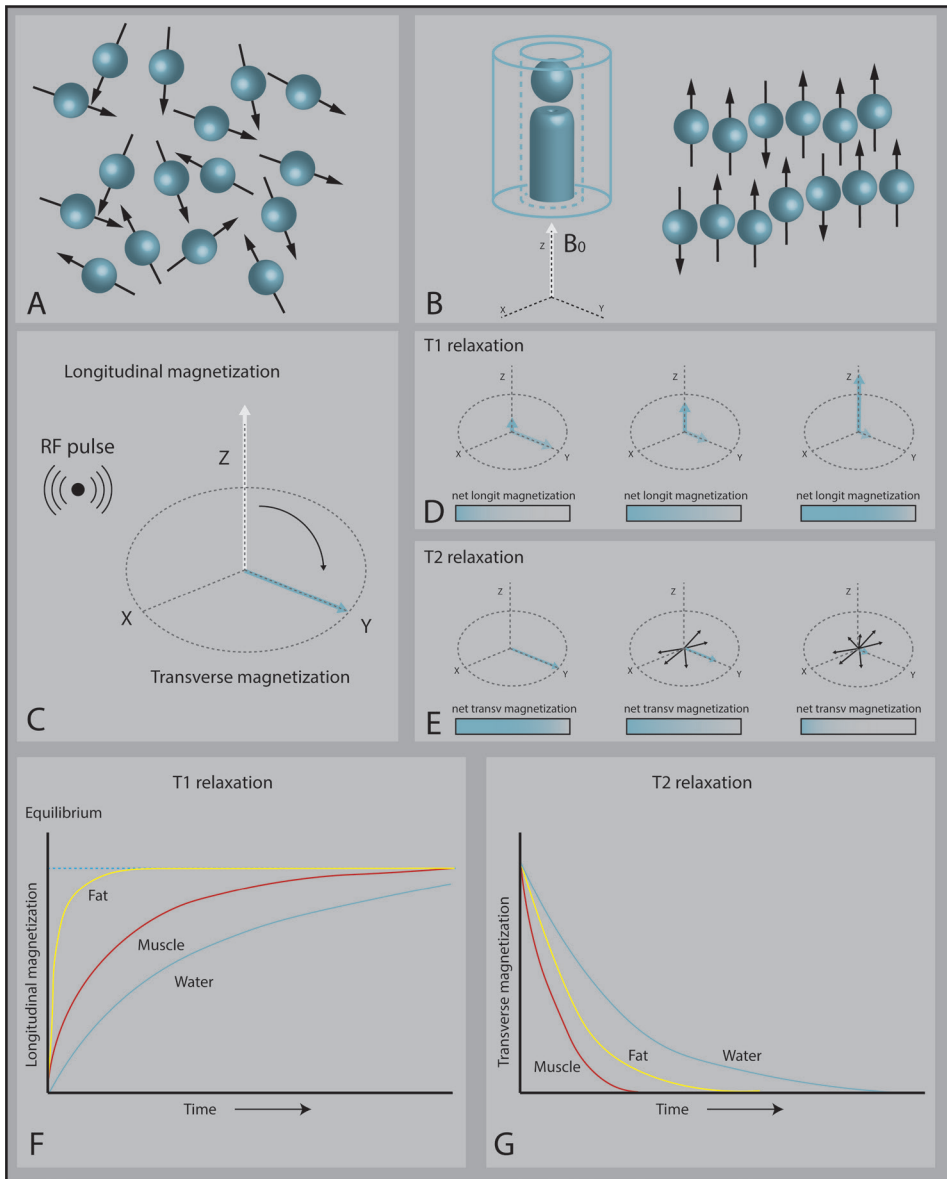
physical aspects of magnetic resonance imaging. Randomly orientated tissue protons (A). Alignment of the tissue protons to the longitudinal magnetic field B_0 of the MRI (B). After administration of a radiofrequency (RF) pulse, the protons are coherently aligned perpendicular to the magnetic field; the transverse magnetic field (C). After turning of the RF pulse, the protons return to their alignment in the magnetic field B_0 (D). Protons lose their coherence in the transverse magnetic field, and the net transverse magnetic field is lost (E). T1 recovery curves for different types of tissue. T2 decay curves for different types of tissue. Adapted from: Rosmalen van, M. (2021). Magnetic resonance imaging to characterize chronic inflammatory neuropathies. Thesis
